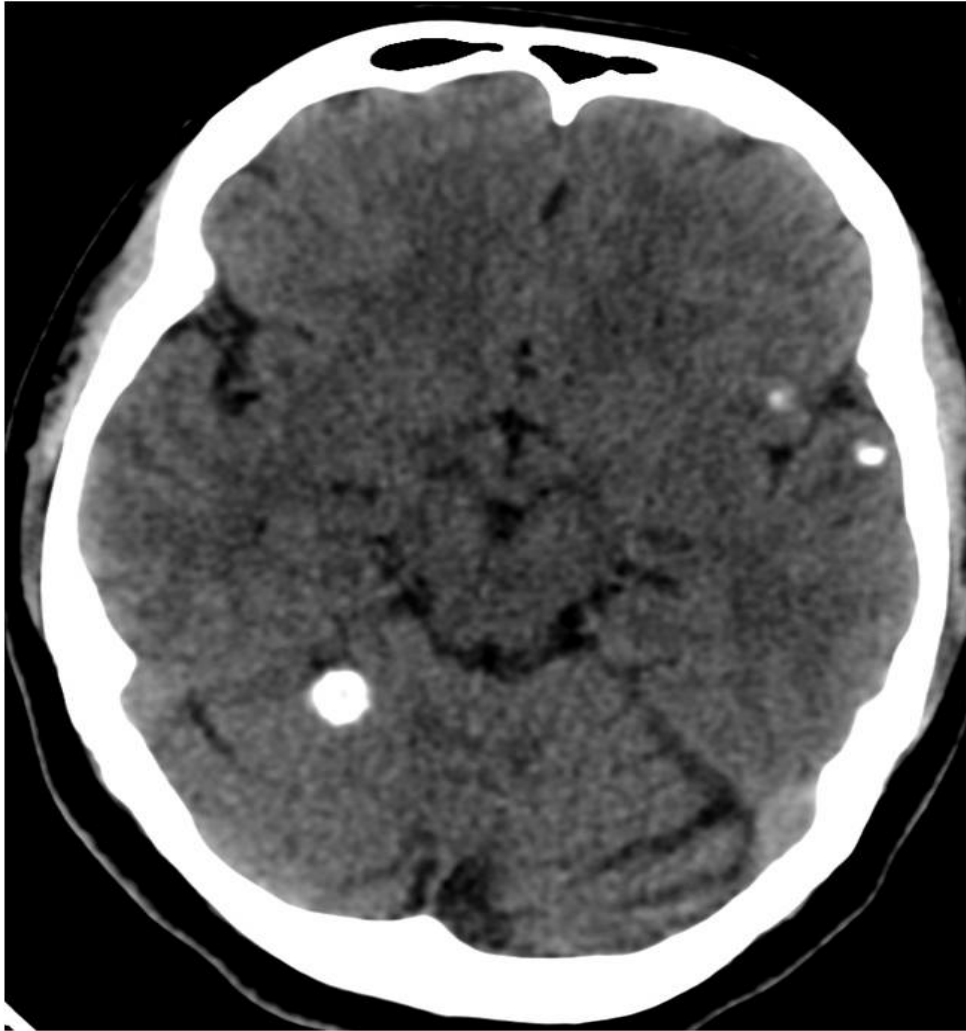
Plain CT brain axial image show calcified nodules in right cerebellar hemisphere and left frontal and temporal lobes
